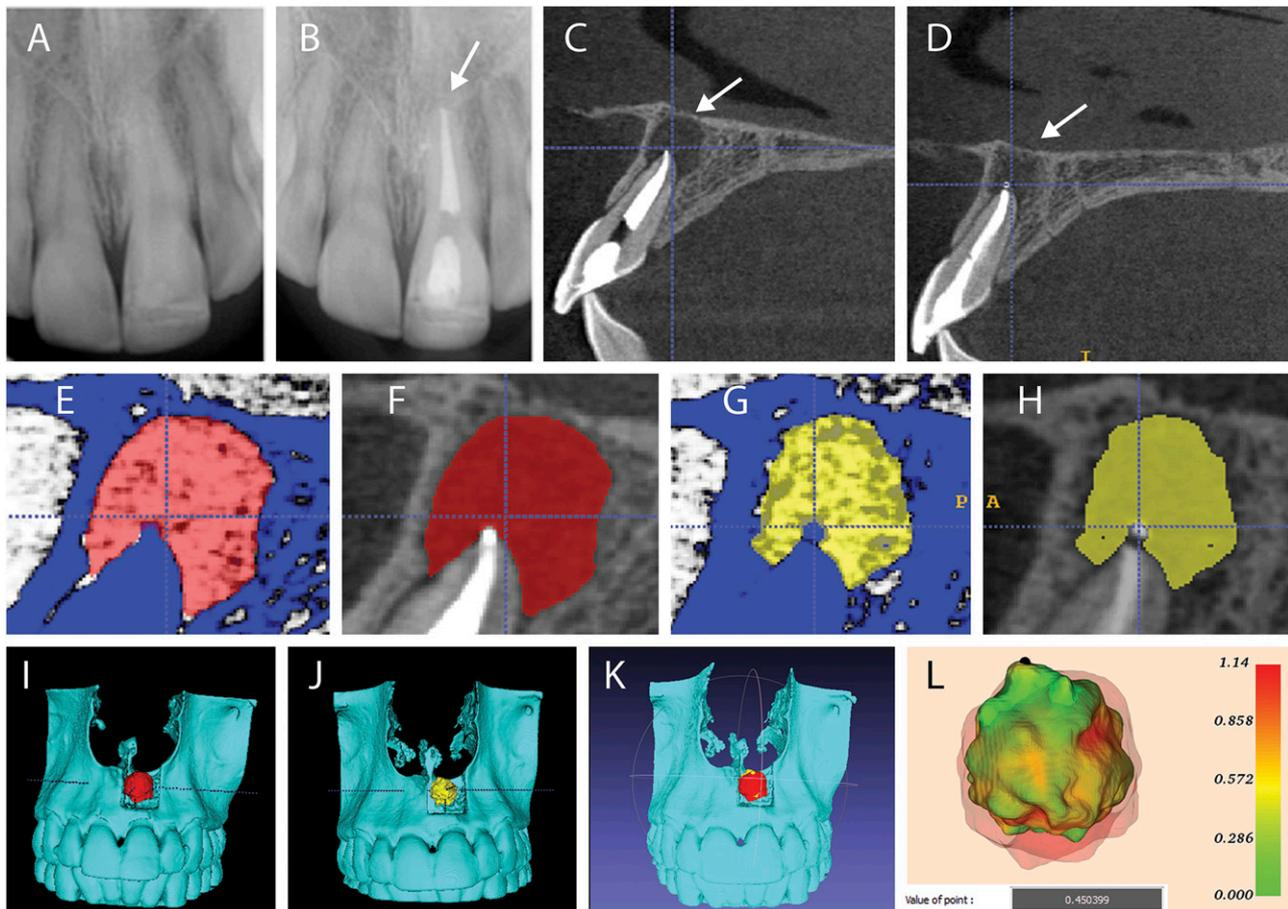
Post-processing of CBCT imaging in Case 2: (a) Digital periapical radiography failed to clearly show the periapical lesion associated with the roots of tooth no. 21 before the endodontic treatment. (b) Soon after the treatment, the digital periapical radiography showed a radiolucent image associated with periapical region (arrow). (c) A CBCT sagittal slice (T0) demonstrating the periapical lesion near the floor of the nasal cavity (arrow) soon after the treatment. (d) A CBCT sagittal slice (T1). Arrow indicates the periapical lesion regression after 4 months of treatment. (e–h) Segmentation using threshold tool soon after the treatment (red label) and 4 months later (yellow label). (i, j) Virtual 3D models constructed soon after the treatment and 4 months later. (k) Virtual 3D models aligned and overlapped. (l) Buccal view of virtual 3D model of periapical lesion before (translucent) and after the treatment (colourful). Qualitative and quantitative assessment by colour maps and “point value” tool revealed a volumetric reduction of the lesion in the buccal view.
